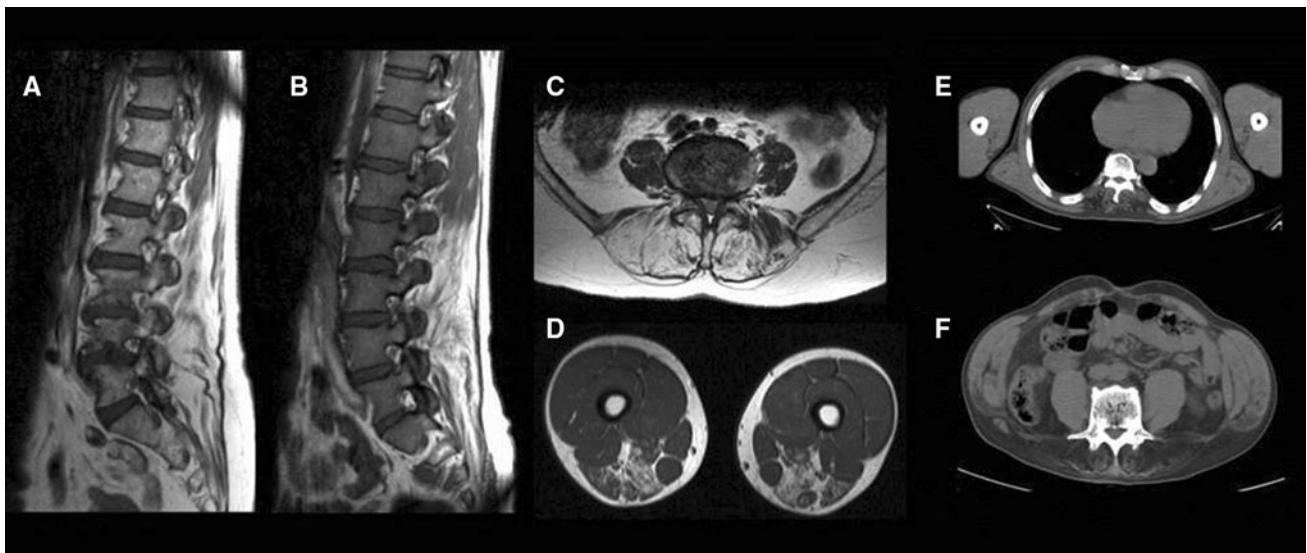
Muscle MR (a–d) and CT (e–f) imaging findings, Patients one (b, d), two (a, c) and five (e–f). There is marked involvement of the thoracic and/or lumbar paravertebral muscles (a–c, e–f). Patient one shows additional posterior thigh involvement (d)
